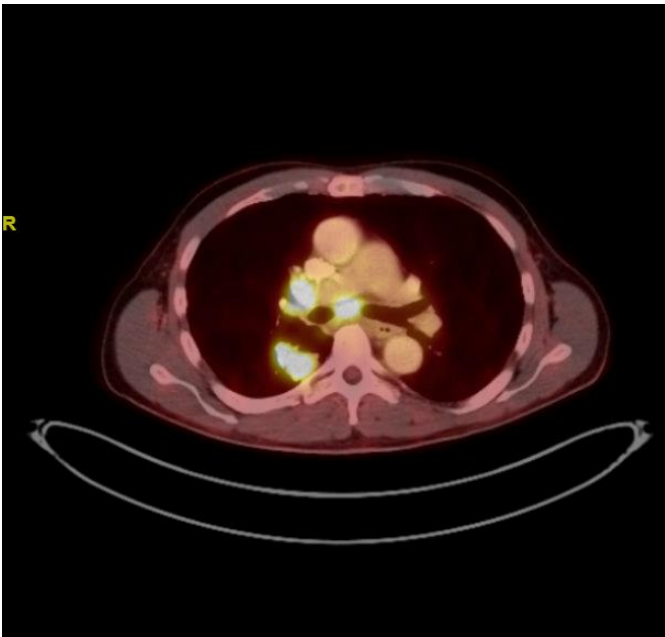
PET CT scan with FDG-avid right lower lobe lung mass and mediastinal and hilar adenopathy.
